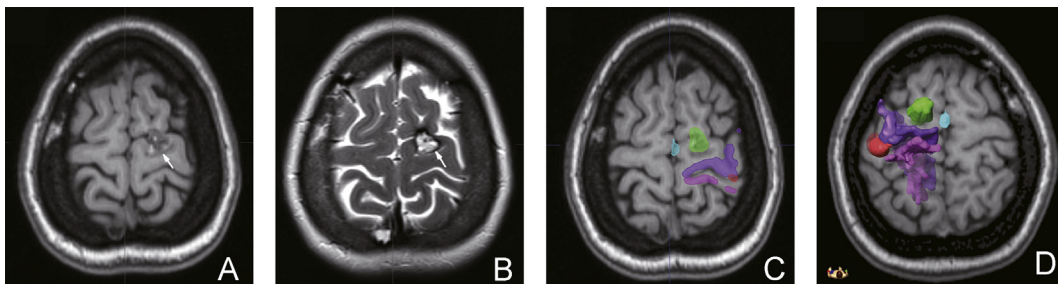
A 32-year-old female patient (Patient 2 in Table 1) presented with pharmaco-resistant epilepsy. A–B. Conventional MRI showed a mixed-signal lesion (white arrow) with a surrounding hypointense rim in the left supplementary motor area. C–D. A 3D reconstructed view revealed the relationships between the lesion (green) and the hand cortex (red), corticospinal tracts (purple), medial lemniscus (pink), and foot cortex (sky blue).
